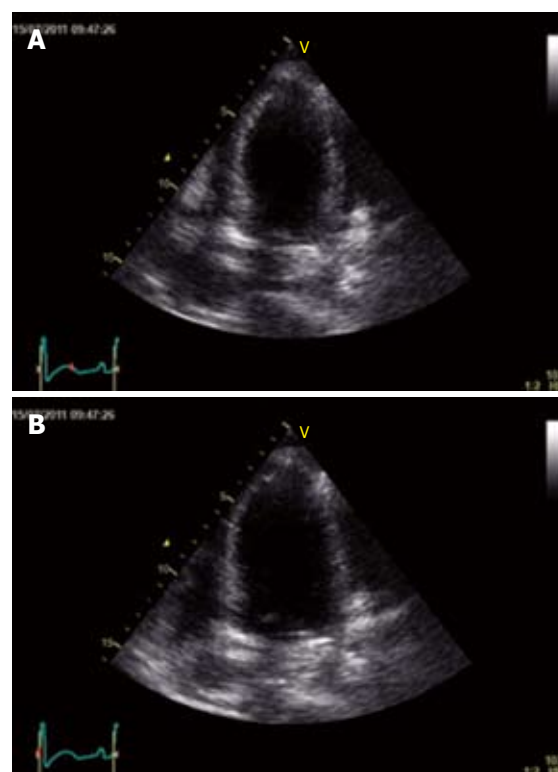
Baseline echocardiography recorded at the end of systole (A) and diastole (B) showing impairment of contractility of all distal-apical segments, but sparing the base and midventricular regions.
